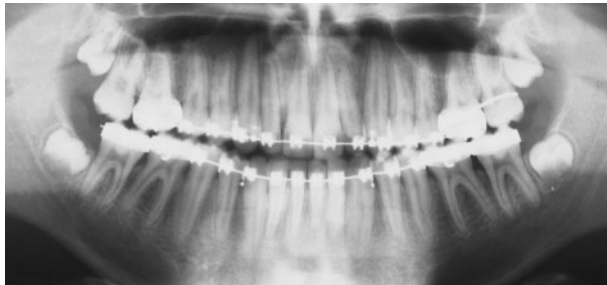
Case report 2: near end-of-treatment panoramic radiograph
